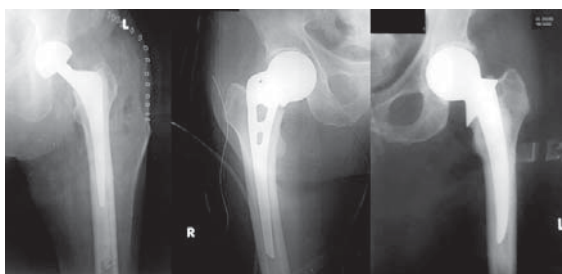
Post-operative X-rays of the three hemi-arthroplasty implants. Left: Cemented bipolar, Middle: Uncemented Austin Moore, Right: Cemented Thompson
